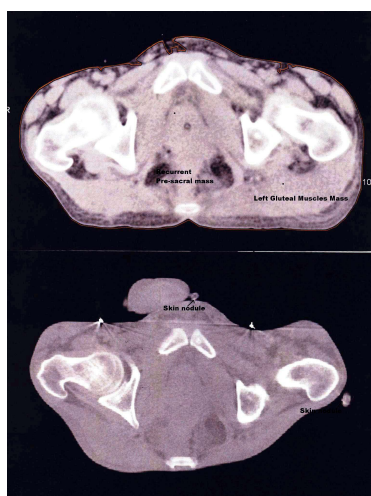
CT scan showing skin nodules and left gluteal muscles mass.
